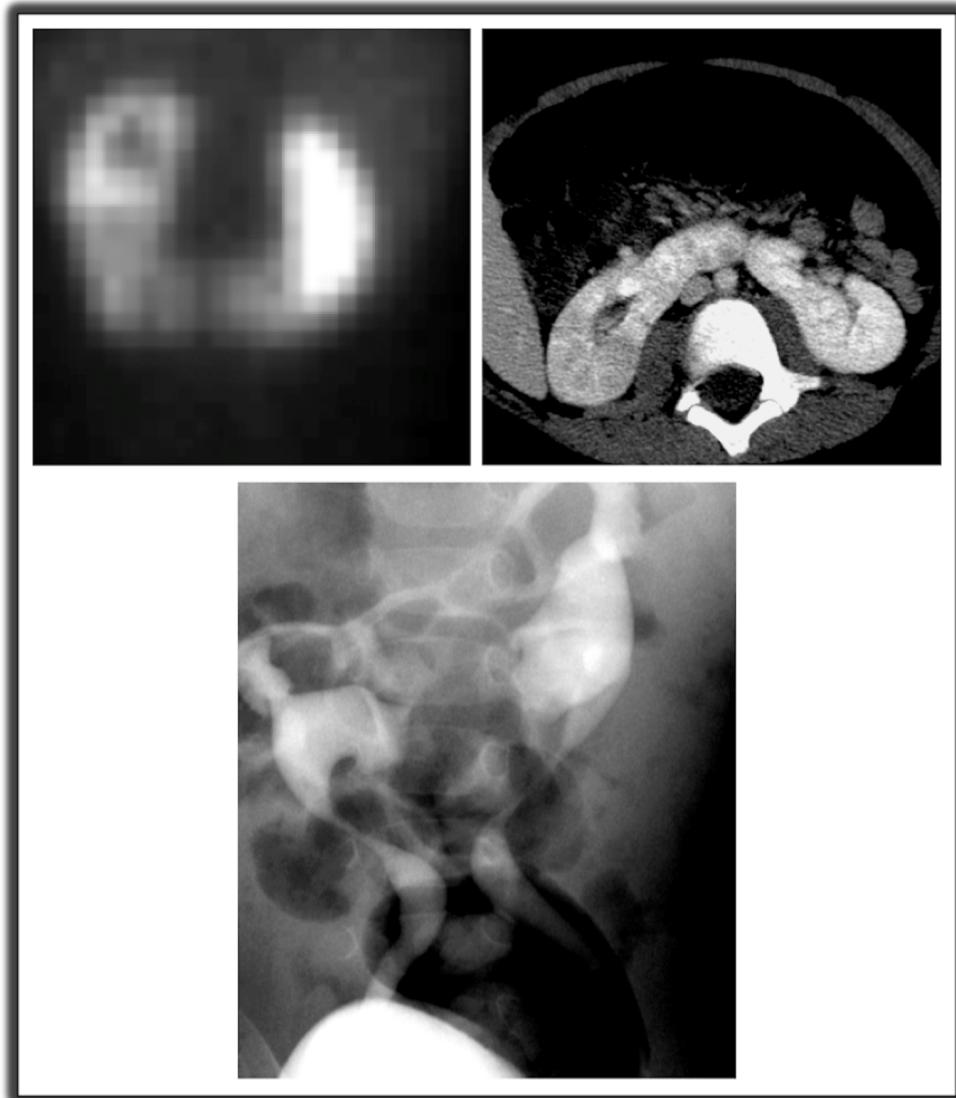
Images of horseshoe kidney on DMSA (upper left), CT (upper right), and VCUG (lower). Note the medially directed calyces on VCUG.
